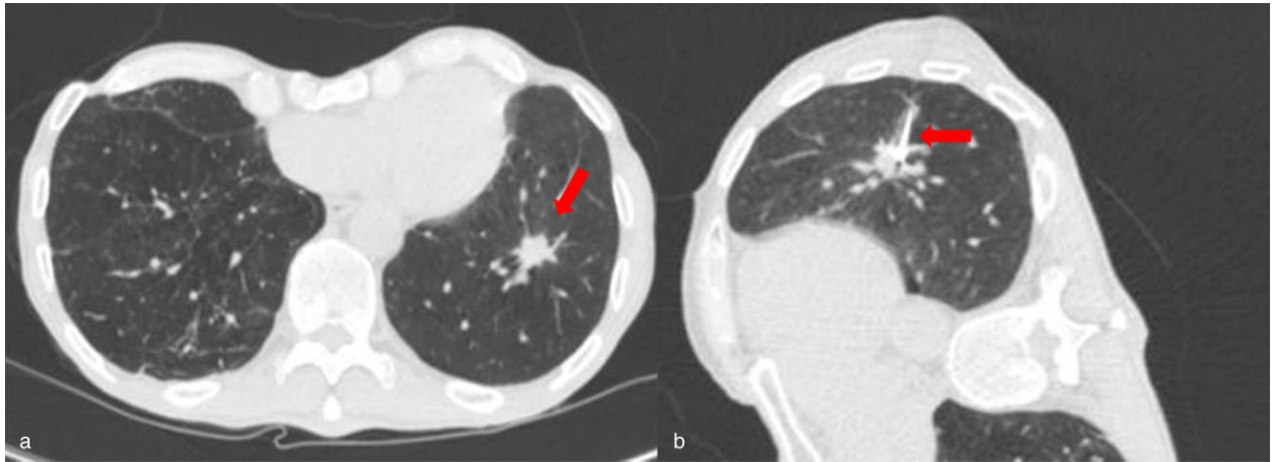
(a) Chest computed tomography scan showing neoplasm of the residual lower lobe, (b) with the 17G non-coring needle with integrated radiofrequency-antenna placed by the tip into the lesion.
